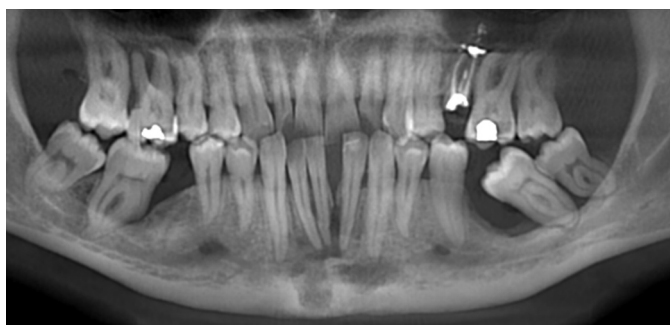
Ten-month follow-up, panoramic radiograph showing reduction of bone loss after chemotherapy (compare to Fig. 2).
